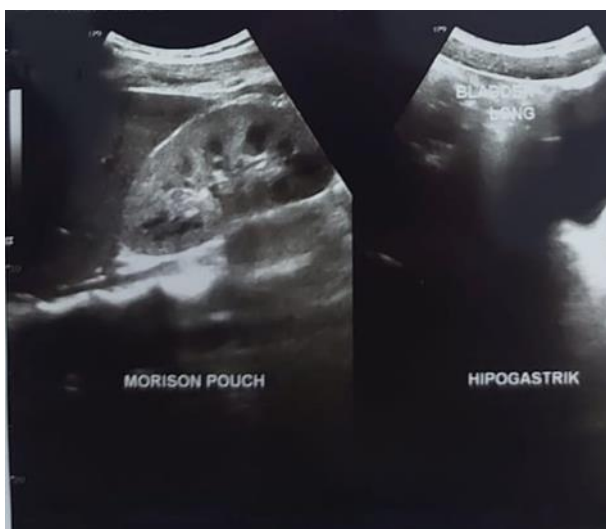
Patient's Abdominal Ultrasound result. Right and left kidney: normal shape and size.
